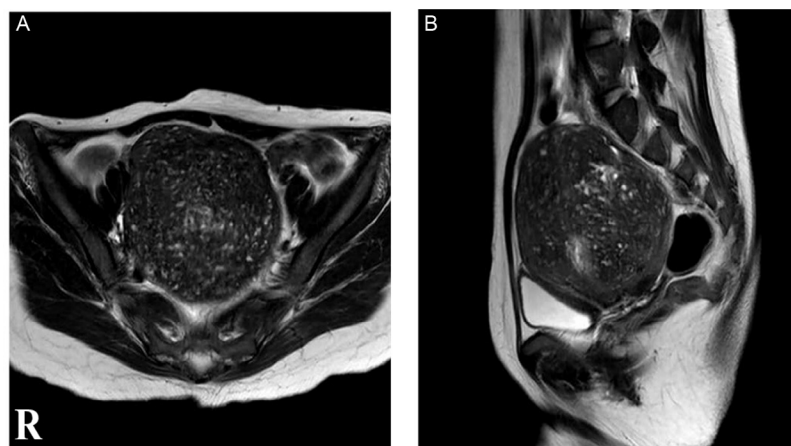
Lower abdomen MRI T2 highlight image (day 2). 10 \times 10 cm uterine adenomyosis with numerous small bleeding inside (A, horizontal cut; B, arrowhead). Abbreviation: MRI, magnetic resonance imaging.
